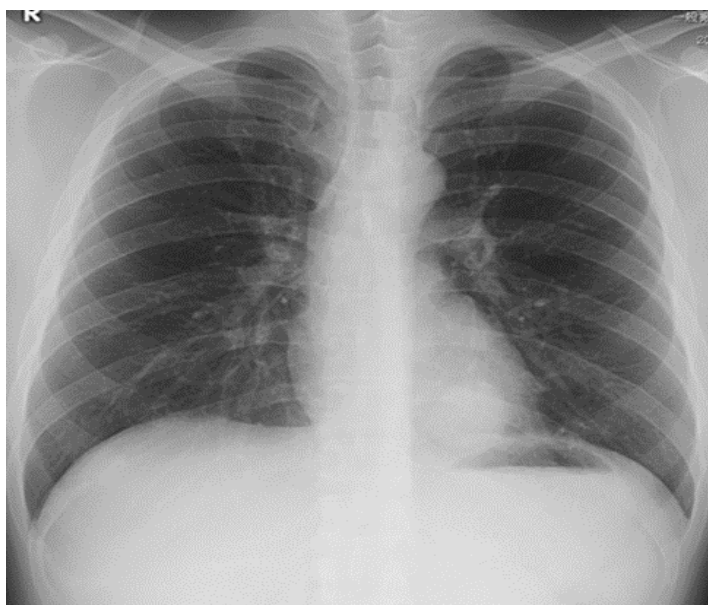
Chest roentgenogram showed a mass lesion in the left lower lung field.
